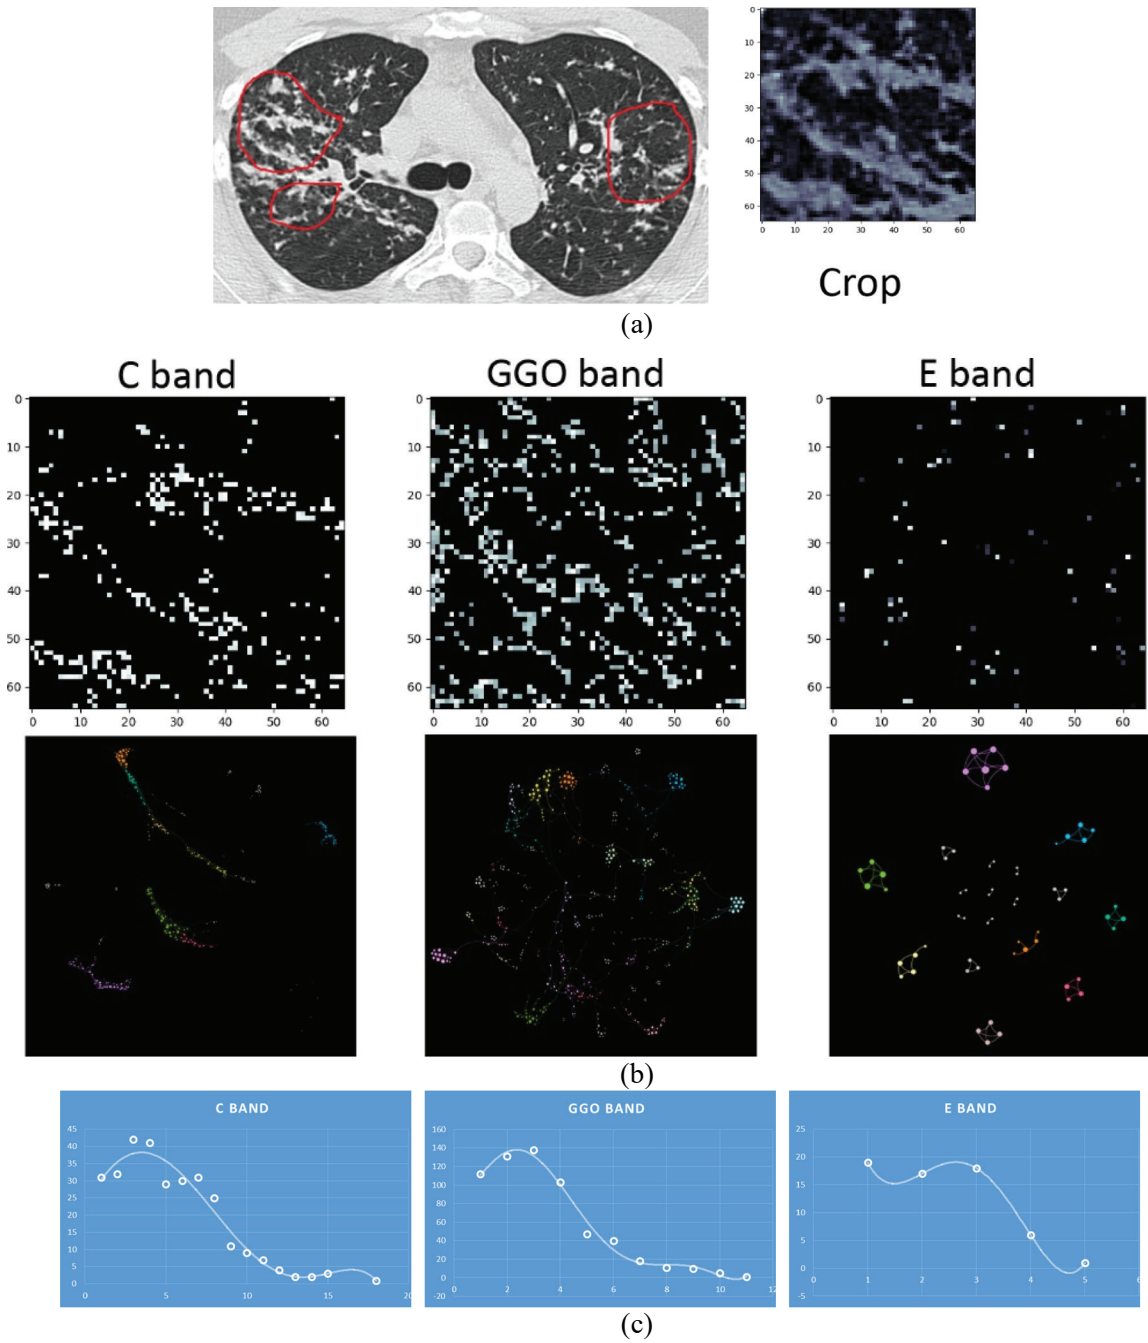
Axial HRCT Sarcoidosis patient (a) relevant slice (b) CN on all three bands (c) Degree distribution plots (lesion intensity).
